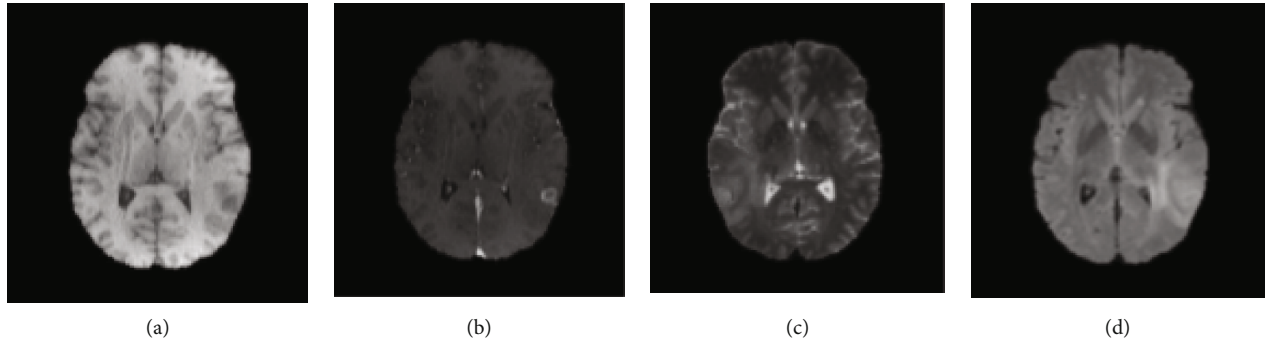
MRI of glioma: (a) T1-weighted, (b) postcontrast T1-weighted, (c) T2-weighted, and (d) FLAIR.
